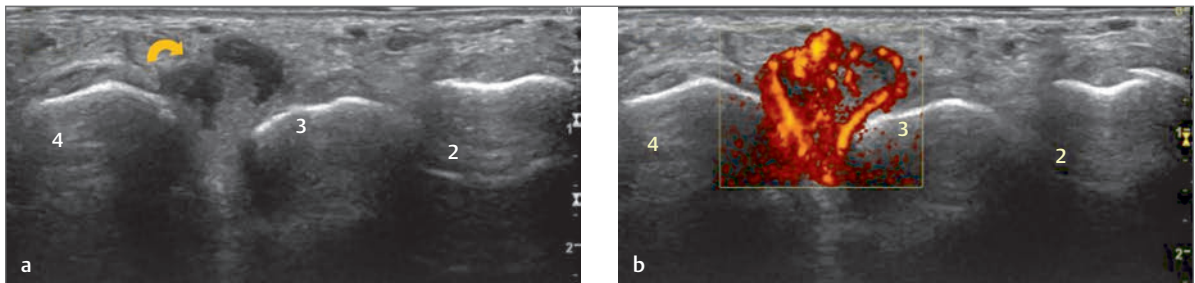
(a) Transverse image of the second, third, and fourth metatarsal heads. No transverse pressure has been applied to the metatarsal heads but a low echo foci may be seen to extend from between the fourth and third metatarsal heads (*curved arrow*). (b) With Power Doppler imaging the low echo foci demonstrates a marked internal vascularity. Both images are in keeping with an intermetatarsal bursa. 4, 3, 2, fourth, third, and second metatarsal head; curved arrows, intermetatarsal bursa.
